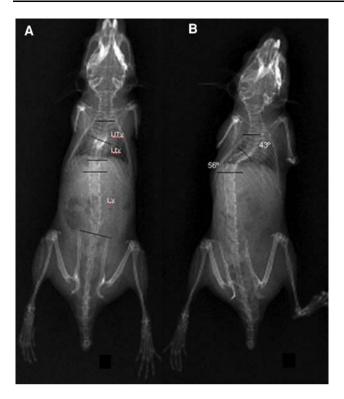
a Antero-posterior X-rays: anatomical nomenclatures of the spinal curvatures. b Antero-posterior X-rays: Cobb angle measurements of the curvatures. UpT upper thoracic, LoT lower thoracic, Lx lumbar
